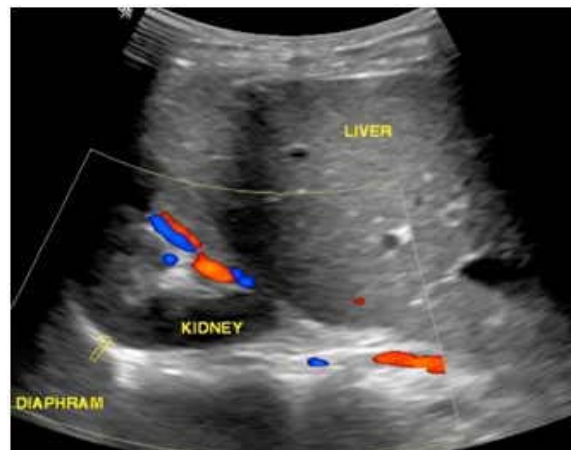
Ultrasound with color doppler of right upper abdomen shows right kidney between right diaphragm (arrow) and liver suggestive of right subdiaphragmatic kidney.
